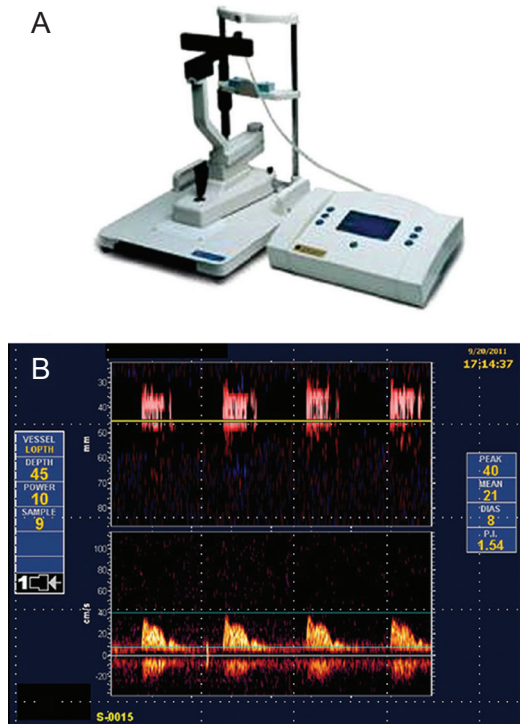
(A) The pulsatile ocular blood flow analyzer (Paradigm Medical Instruments, Salt Lake City, UT, USA), (B) the transcranial Doppler image using a TCD150M device (Spencer Technologies, Seattle, WA, USA). This case shows a peak systolic velocity (PEAK), mean flow velocity (MEAN), end diastolic velocity (DIAS) and pulsatility index (PI) of the left ophthalmic artery at 1 week after the administration of cilostazol.
